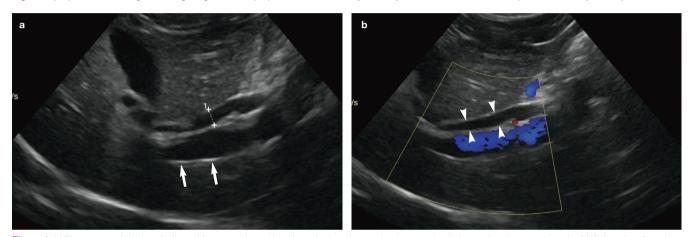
(a) The common bile duct (indicated by measuring calipers) can be found ventral to the portal vein (arrows) at the porta hepatis. (b) Colour flow Doppler confirms the presence of hepatopetal flow within the portal vein (ie, flow travelling from right to left in the image) and an absence of flow within the common bile duct (arrowheads)
